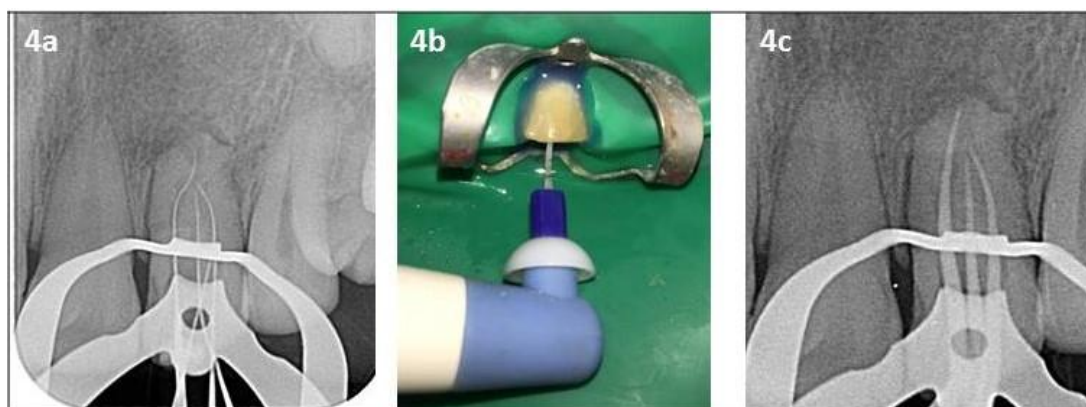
Working length by periapical radiography confirming 4 canals, b: NaOCl agitation with Endoactivator (Dentsply), c: Master cone by periapical radiography
